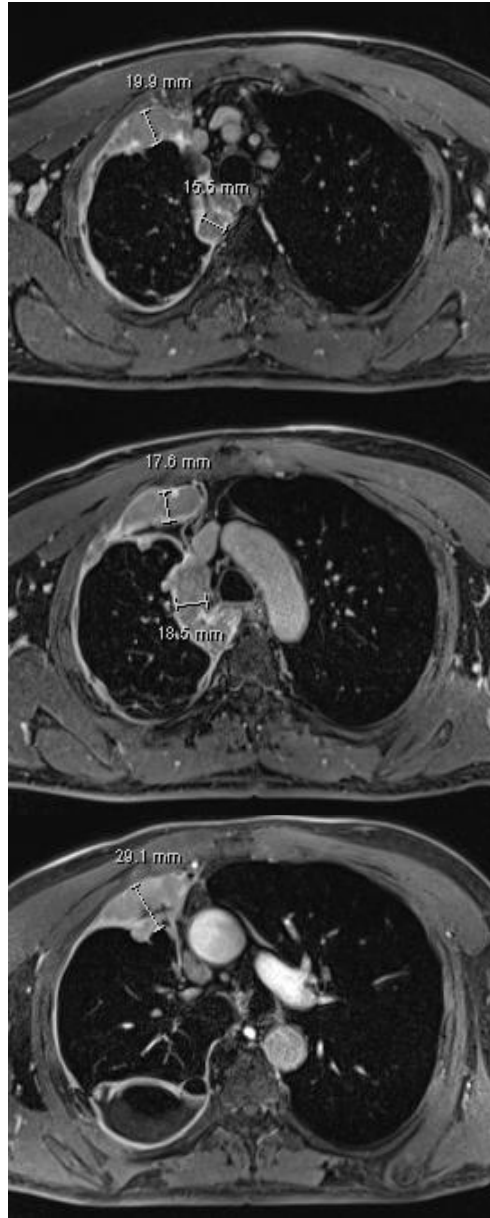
An example of the MPM measurements according to the mRECIST. Post-contrast T1-weighted fat-sat images in the axial plane of the thorax. Total measurements: $20 + 16 + 18 + 18 + 29 = 101$ cm. At reassessment, it is important to perform the measurements in the same position.
